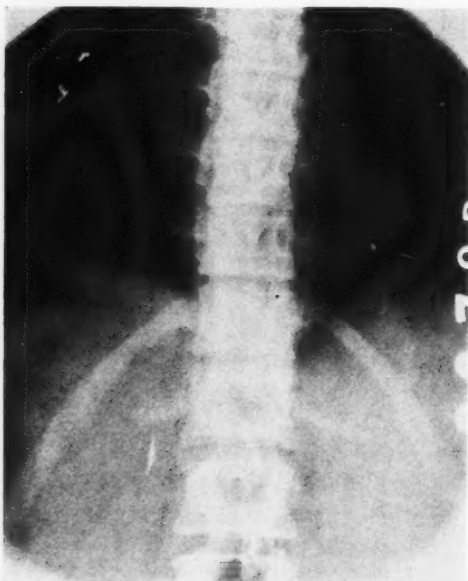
Antero-posterior roentgenogram of the spine in Case 4. Note the small abscess just above the diaphragm and the barely perceptible changes in the bodies of the ninth and tenth thoracic vertebrae.
